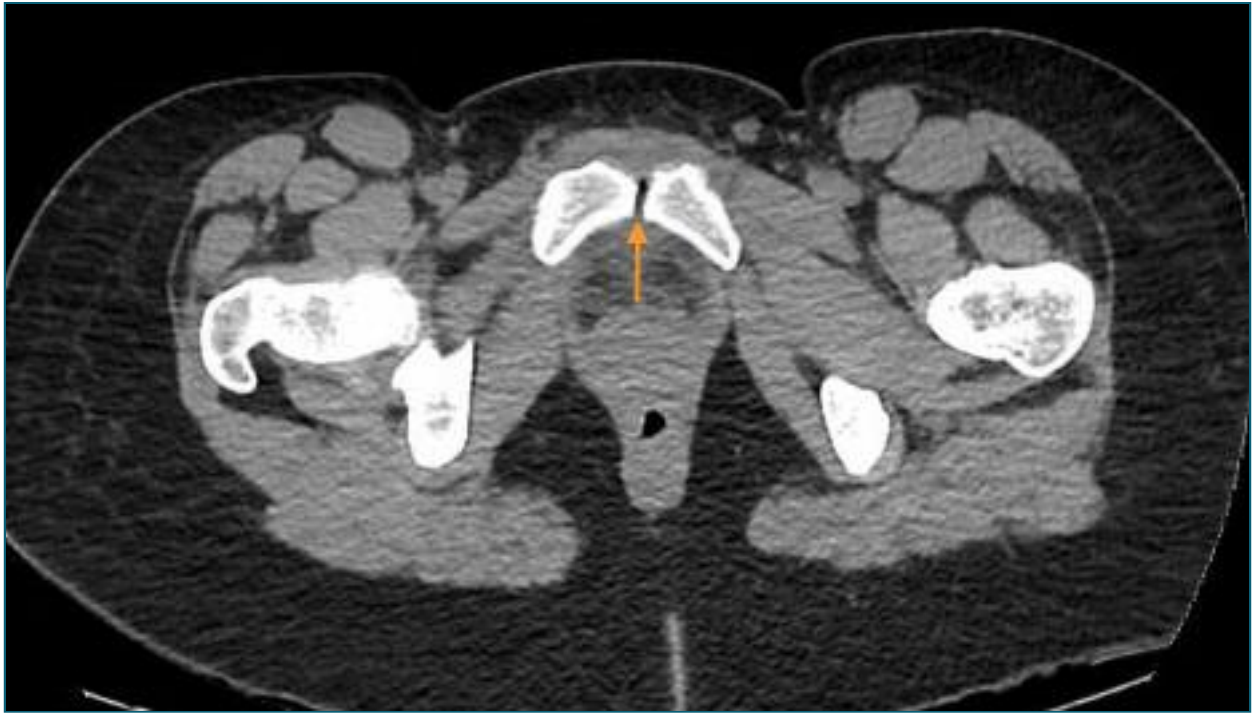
Pelvic CT scan. CT scan demonstrating intra-articular air and high density of soft tissues.
